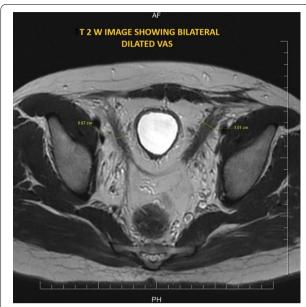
Axial MRI pelvis showing extensive pelvic lipomatosis with bilateral dilated vas. The diameter of dilated right vas was 0.67 cm and left vas was 1.01 cm
